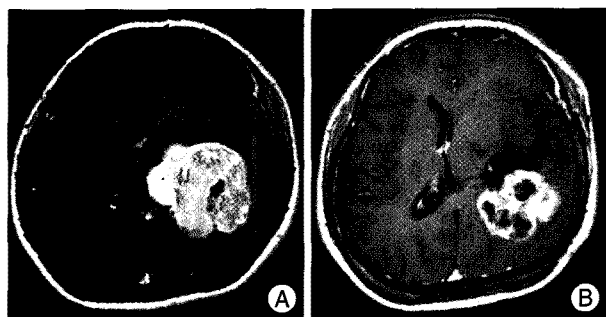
A : Gadolinium-enhanced cranial magnetic resonance imaging (MRI) on January 2003 reveals a large tumor with strong homogenous enhancement in the trigone of the left lateral ventricle. B : Gadolinium-enhanced cranial MRI on March 2006 reveals recurrent tumor with strong heterogeneous enhancement, with an irregular tumor outline.
